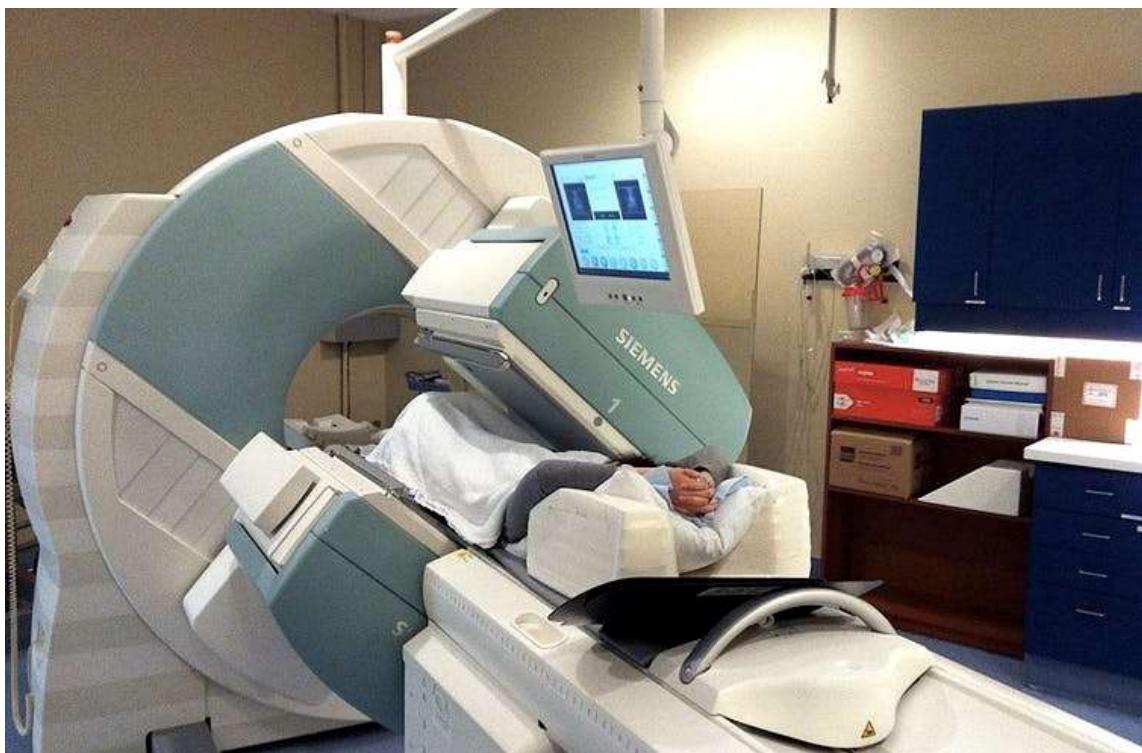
Single-photon emission computed tomography (SPECT) machine in action.
